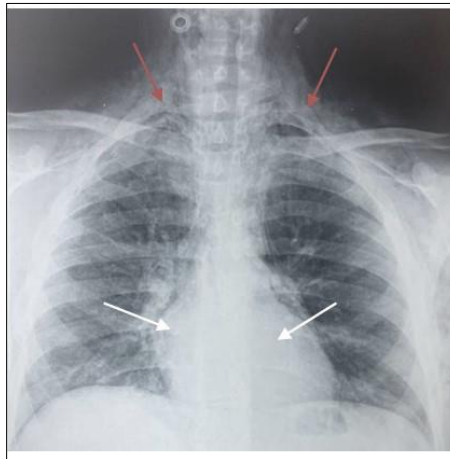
Chest X-ray of the patient revealing subcutaneous emphysema (Red arrows), and pneumomediastinum (White arrows)
